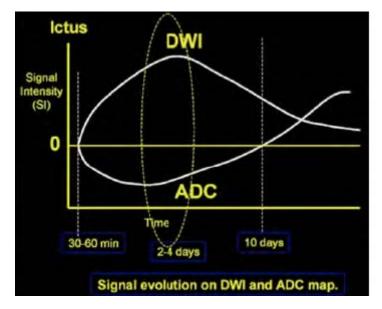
Signal evolution on DW-MRI
